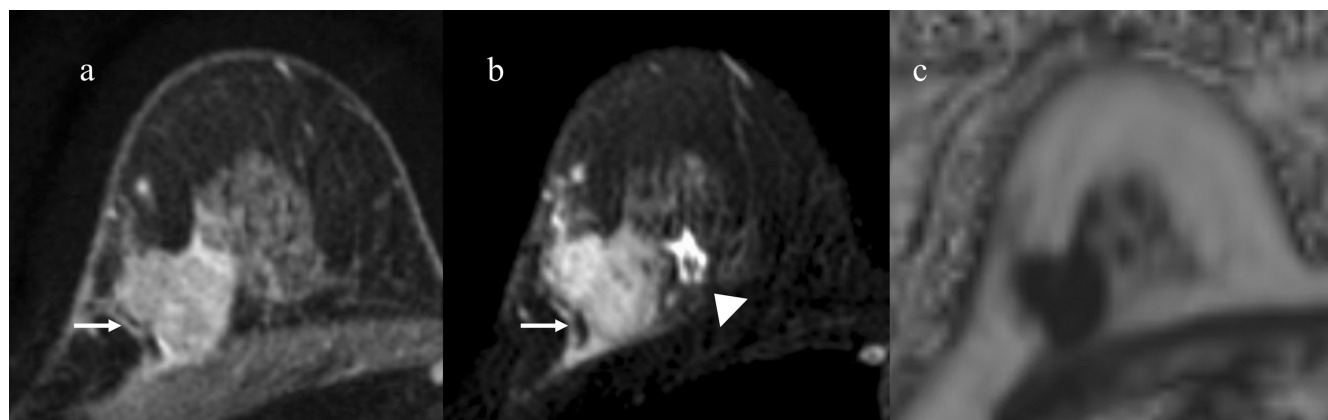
Preoperative right breast MR images in a 64-year-old woman with a 29-mm invasive ductal carcinoma (triple negative type). Axial fat-suppressed post-contrast T1-weighted image (a) shows a 29-mm high-intensity mass (arrow) in the right breast. The fat-suppressed T2-weighted image (b) shows the high-intensity mass (arrow) with Grade 2 edema (arrowhead) in the right breast, and the corresponding average peritumoral TFF (80.16) on the fat fraction map (c) is low. A local recurrence appeared 1 year and 10 months after surgery. TFF, tumor fat fraction.
